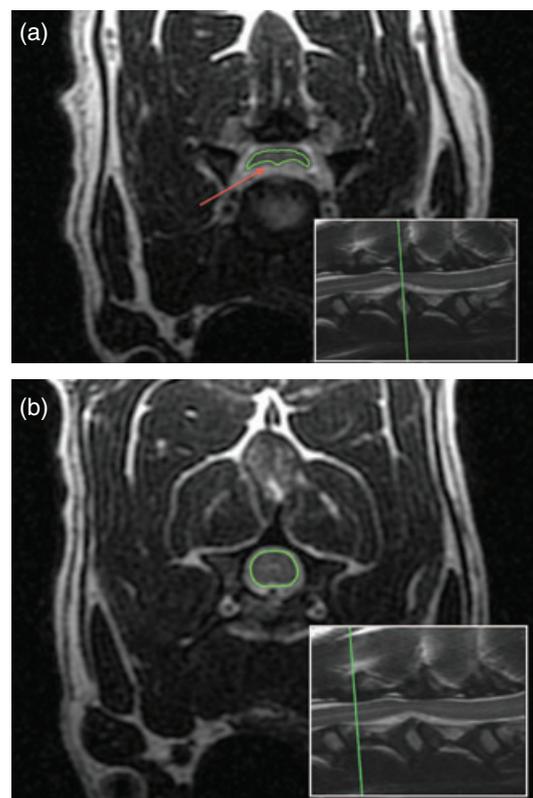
(a) Transverse T2-weighted image with the outlined cross-sectional area of the spinal cord at the level of maximal dorsoventral compression. The suspected extruded material (red arrow) lies symmetrically on the midline ventral to the spinal cord. The image below right shows the cross reference of the transverse view. (b) Transverse T2-weighted image with the outlined cross-sectional area of the spinal cord at the region of the normal spinal cord closest to the site of compression. The image below right shows the cross reference of the transverse view
